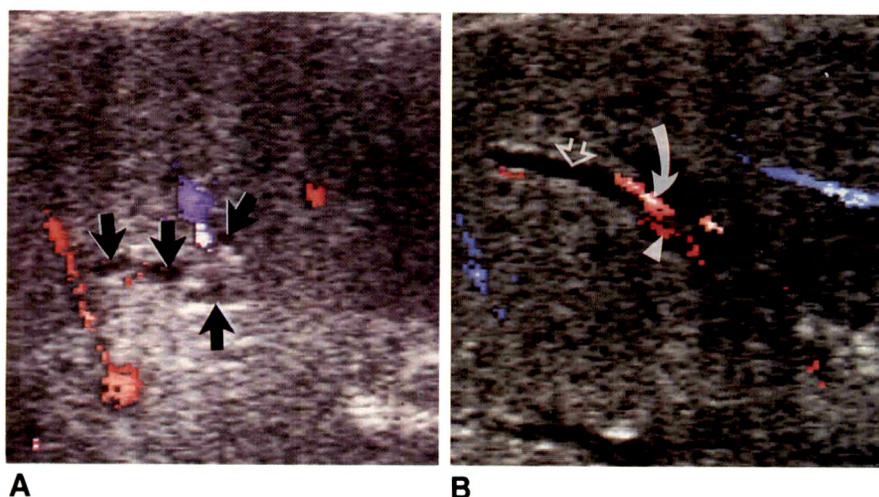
A and B, Transverse color Doppler sonograms of liver. Flow is detected in small arterial and venous structures. No flow is detected within small, dilated intrahepatic ducts. Note ease with which vessels can be differentiated from dilated ducts, even when they are adjacent to one another. Note dilated duct (open arrow in B) adjacent to vessels with color-coded flow. In B, portal vein is shown by arrowhead; curved arrow indicates hepatic artery.
